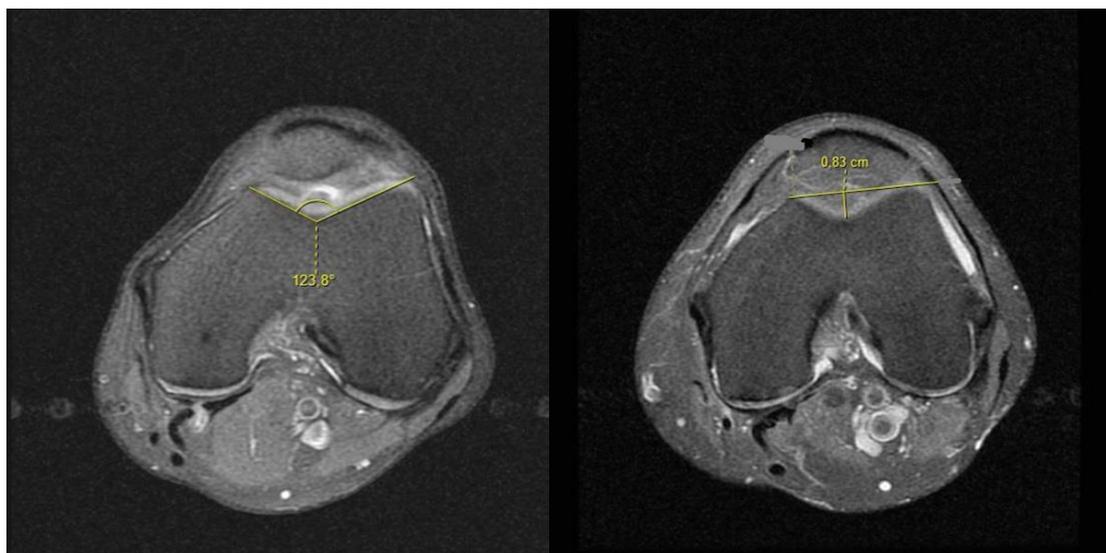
(a-b): MR images shows axial measurements in a 42-year-old man who underwent knee MRI, a. Femoral sulcus angle, b. Trochlear depth
